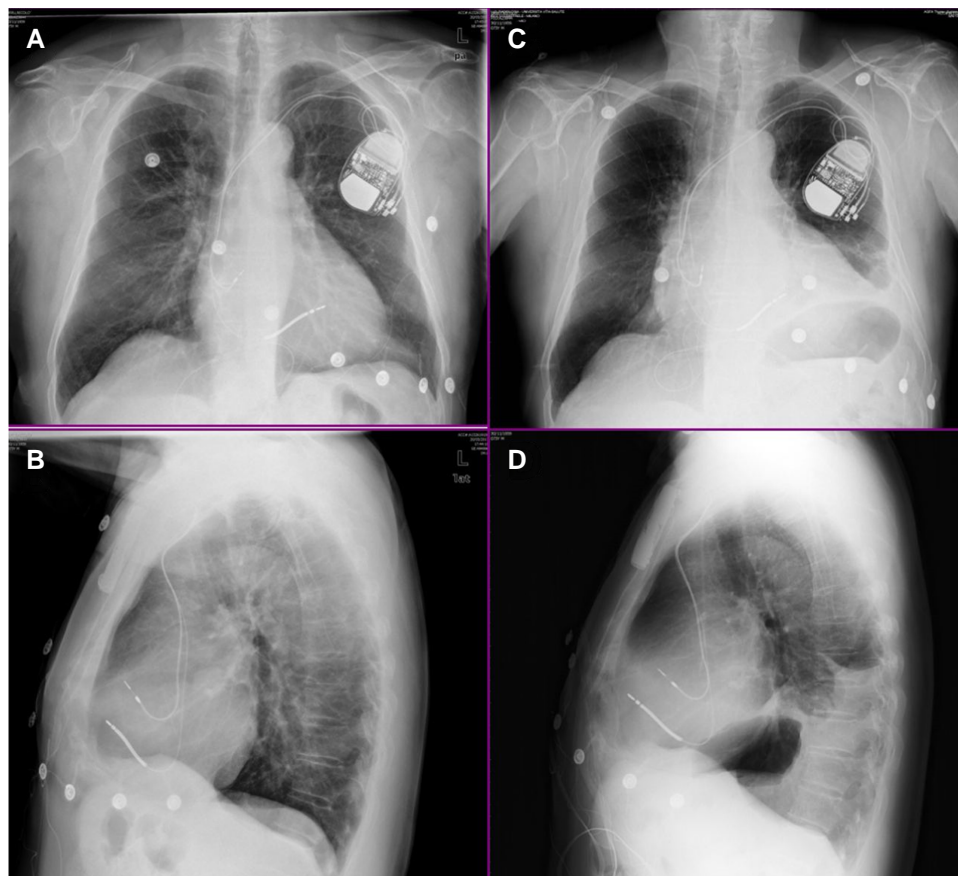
Phrenic nerve palsy after epicardial ablation for refractory ventricular tachycardia. (A and B) Anteroposterior and lateral chest X-rays before the procedure, showing the normal position of the left diaphragm dome. (C and D) Elevation of left hemidiaphragm, particularly in the posterior segment, after epicardial ablation. Note the relative elevation of the gastric bubble after the nerve palsy.
